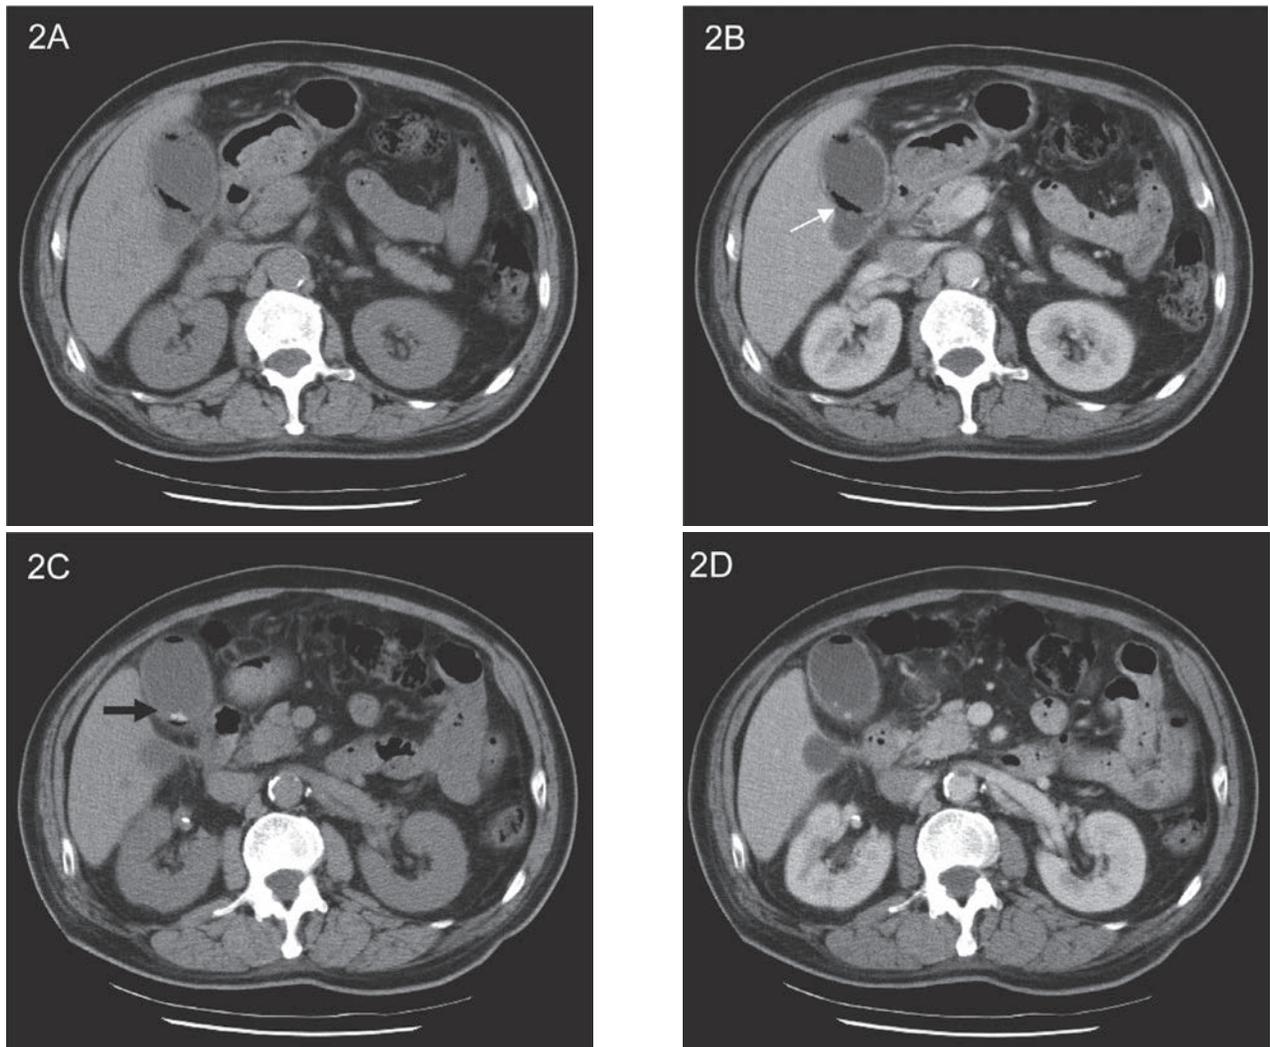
Computed tomography demonstrated thickening of the gallbladder wall with hyperemia, gas within the gallbladder wall and lumen (white arrow), and small gallstones (black arrow). 2A and 2C, without contrast-enhancement; 2B and 2D, with contrast-enhancement.
